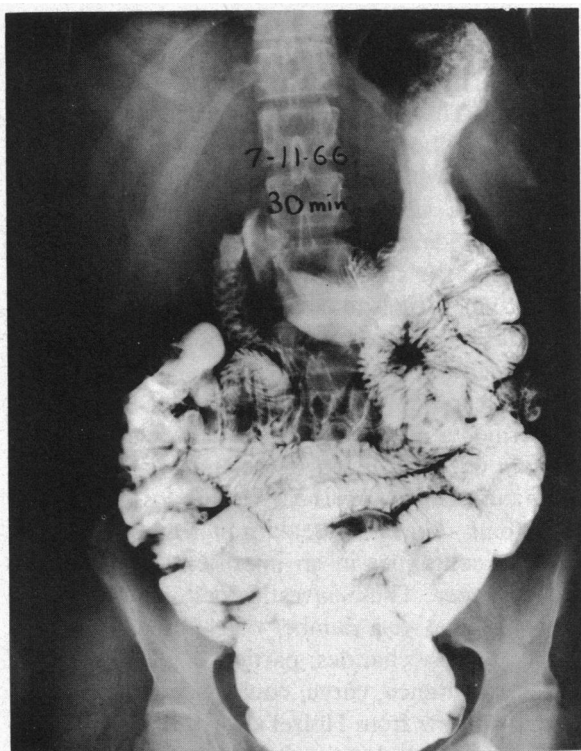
X-ray film with barium preparation (without sugar).
